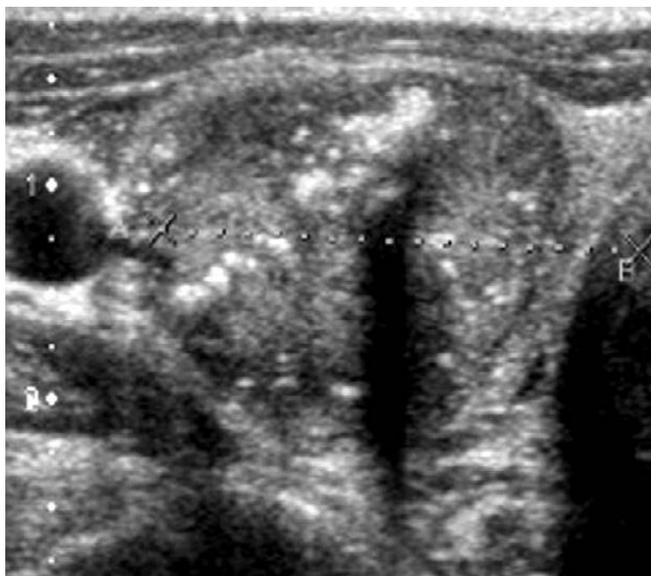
Malignant nodule on ultrasonography showing micro-calcifications in the hypo echoic nodule.
